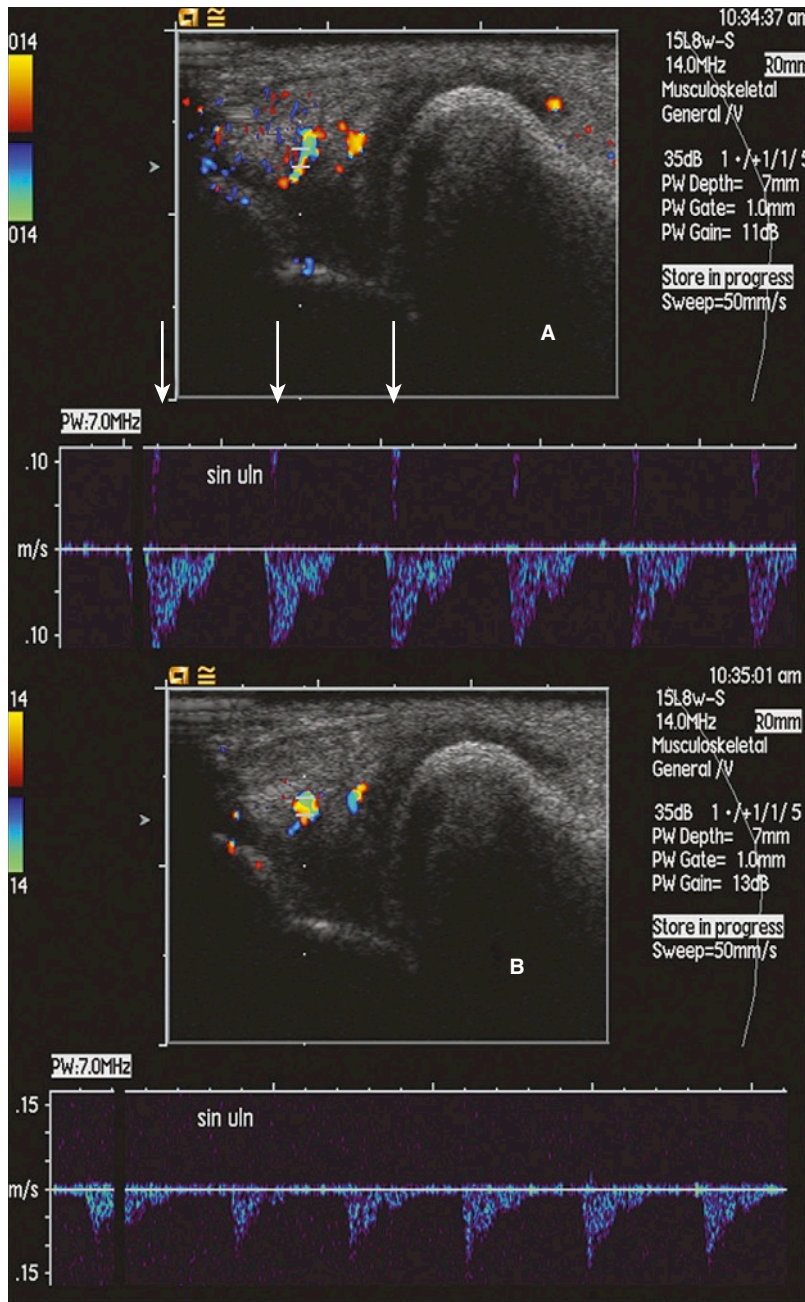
ALIASING IN SPECTRAL DOPPLER. A, The spectral curve folds over, with *arrows* pointing to the aliased signal. B, The methods for overcoming aliasing are the same for spectral and color Doppler. One method is to move the time axis (*x*-axis), thereby devoting the entire range of frequencies on the display to one flow direction.
